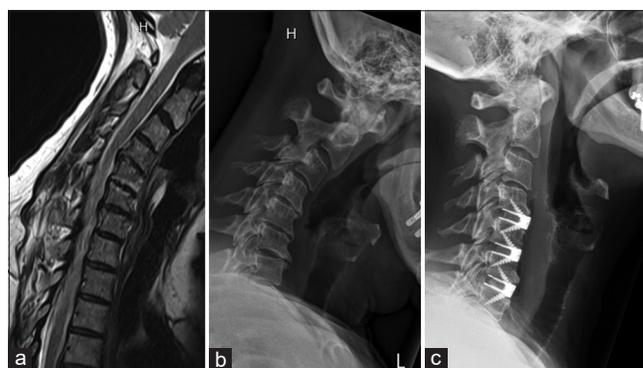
Triple-level anterior cervical discectomy and fusion (anterior cervical discectomy and fusion, Allograft) for degenerative disc disease and foraminal stenosis. (a) Sagittal T2WI magnetic resonance imaging of cervical level (b) sagittal standing X-ray (c) Postoperative X-ray demonstrating implanted anterior cervical discectomy and fusion devices and improved alignment
